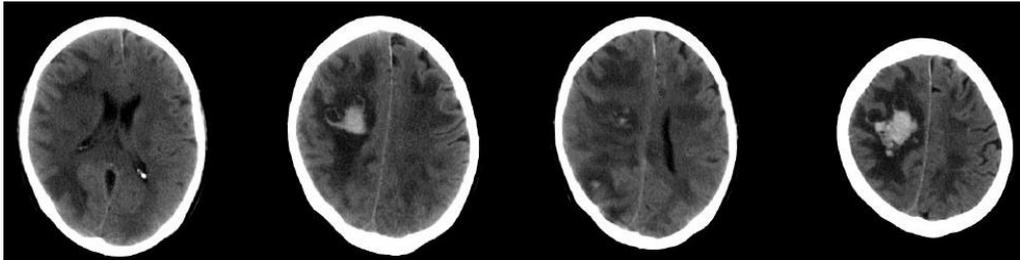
CT head without contrast, post-transplantation, demonstrating an area of hemorrhage in the right frontoparietal lobe with bilateral white matter edema consistent with HPRES.
